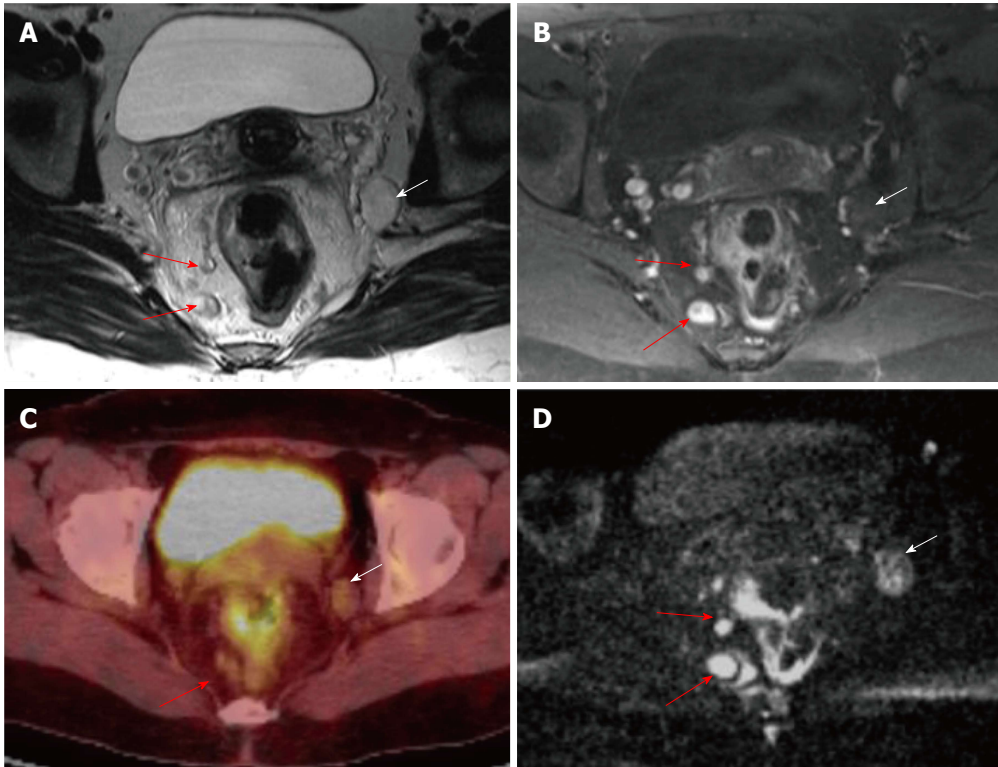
Mesorectal and extramesorectal lymph node involvement in rectal cancer. A: T2-weighted; B: T1-weighted contrast-enhanced axial MR images; C: ^{18}F -FDG PET-CT; D: DWI showing suspicious lymph nodes in mesorectal (red arrows) and extramesorectal areas (white areas). On DWI, extramesorectal lymph node is more remarkable than T2W and contrast-enhanced T1W sequences. DWI: Diffusion-weighted imaging; ^{18}F -FDG PET-CT: ^{18}F -fluorodeoxyglucose positron emission tomography-computed tomography.
